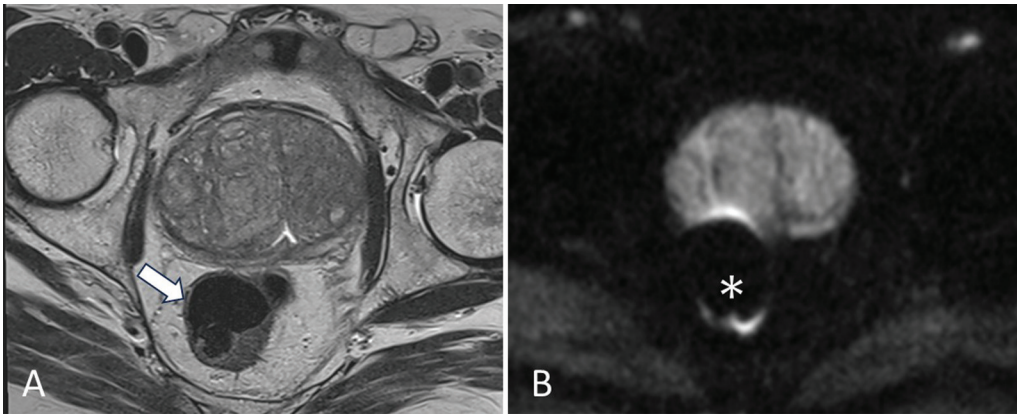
Impact of rectal air. Air pocket (arrow) in the rectum on axial T2-weighted image (T2WI) (A) causing focal distortion on axial diffusion-weighted imaging (DWI) (asterisk) (B).
